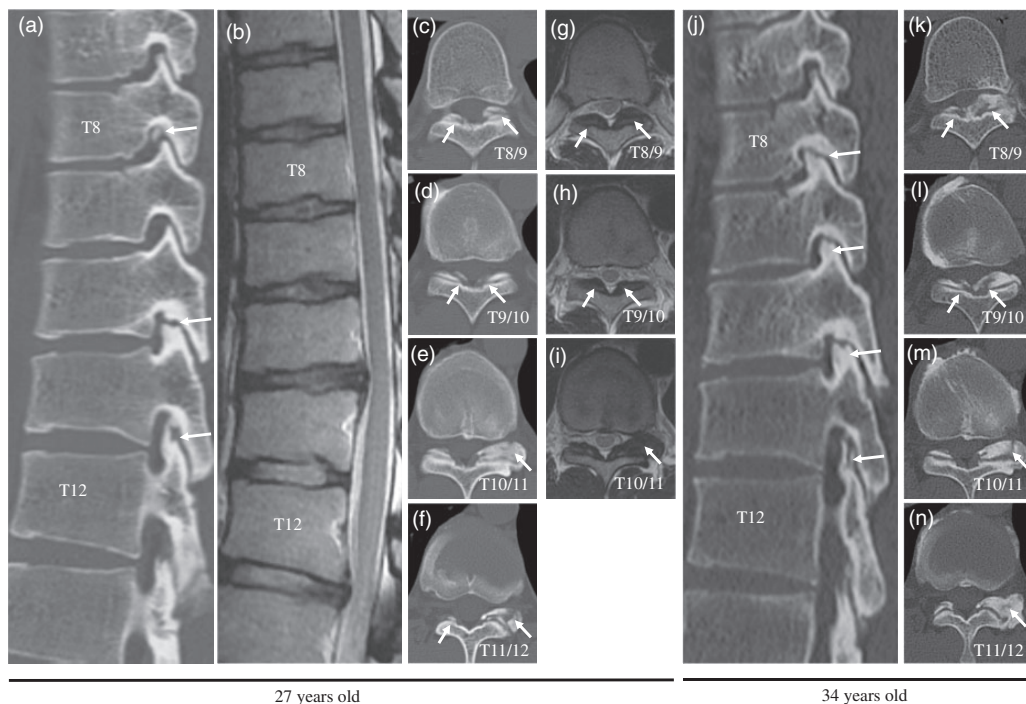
Case 1: Radiological findings in the thoracic spine on computed tomography and magnetic resonance imaging showing the presence of ossification of the ligamentum flavum (arrows). Left parasagittal view (a), sagittal view (b), and axial view at T8/9 (c, g), T9/10 (d, h), T10/11 (e, i), and T11/12 levels (f) of the spine when the patient was 27 years old. Left parasagittal view (j) and axial view at T8/9 (k), T9/10 (l), T10/11 (m), and T11/12 (n) of the spine when the patient was 34 years old.
